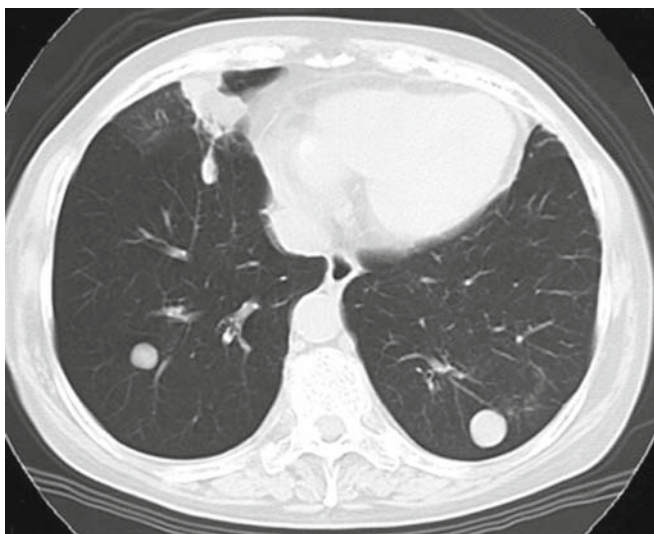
CT scan of the chest 11 years after the initial surgery shows multiple metastases in both lungs
